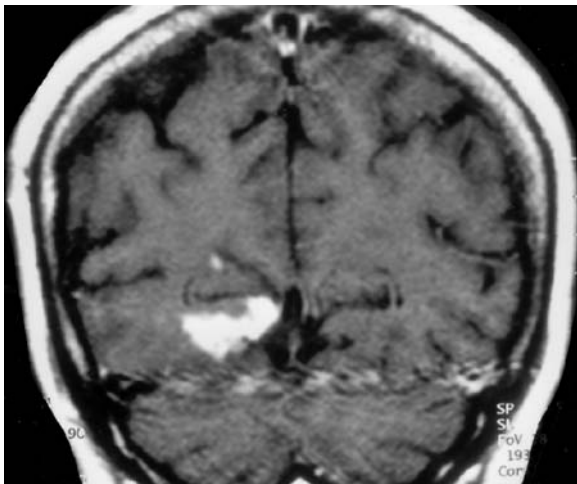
A 54-year-old man with acute hemianopia to the right and hemisymptomatology of the right lower limb. Diagnosis: isolated infarction of the anterior choroid artery. MRI: a Axial T2-weighted view with a hyperintense region, corresponding to the presence of infarction at the temporal horn of the left ventricle (optic radiation, *arrow*), spreading to the posterior part of the internal capsule. b Corresponding T1-weighted, contrast-enhanced image demonstrating BBB disruption with high signal intensity at the site of infarction. (From MÜLLER-FORELL and LIEB 1995)
